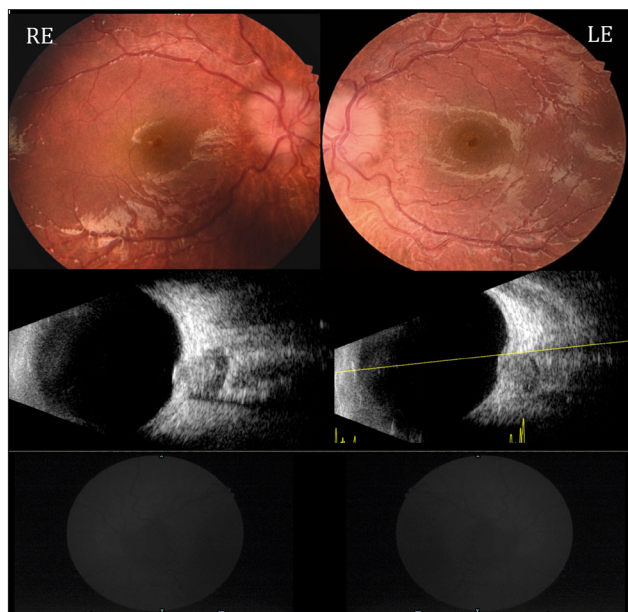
Fundus photos, B-scan ultrasonography and fundus autofluorescence of case 1 demonstrating bilateral optic disc elevation and vascular tortuosity with preserved autofluorescence.
